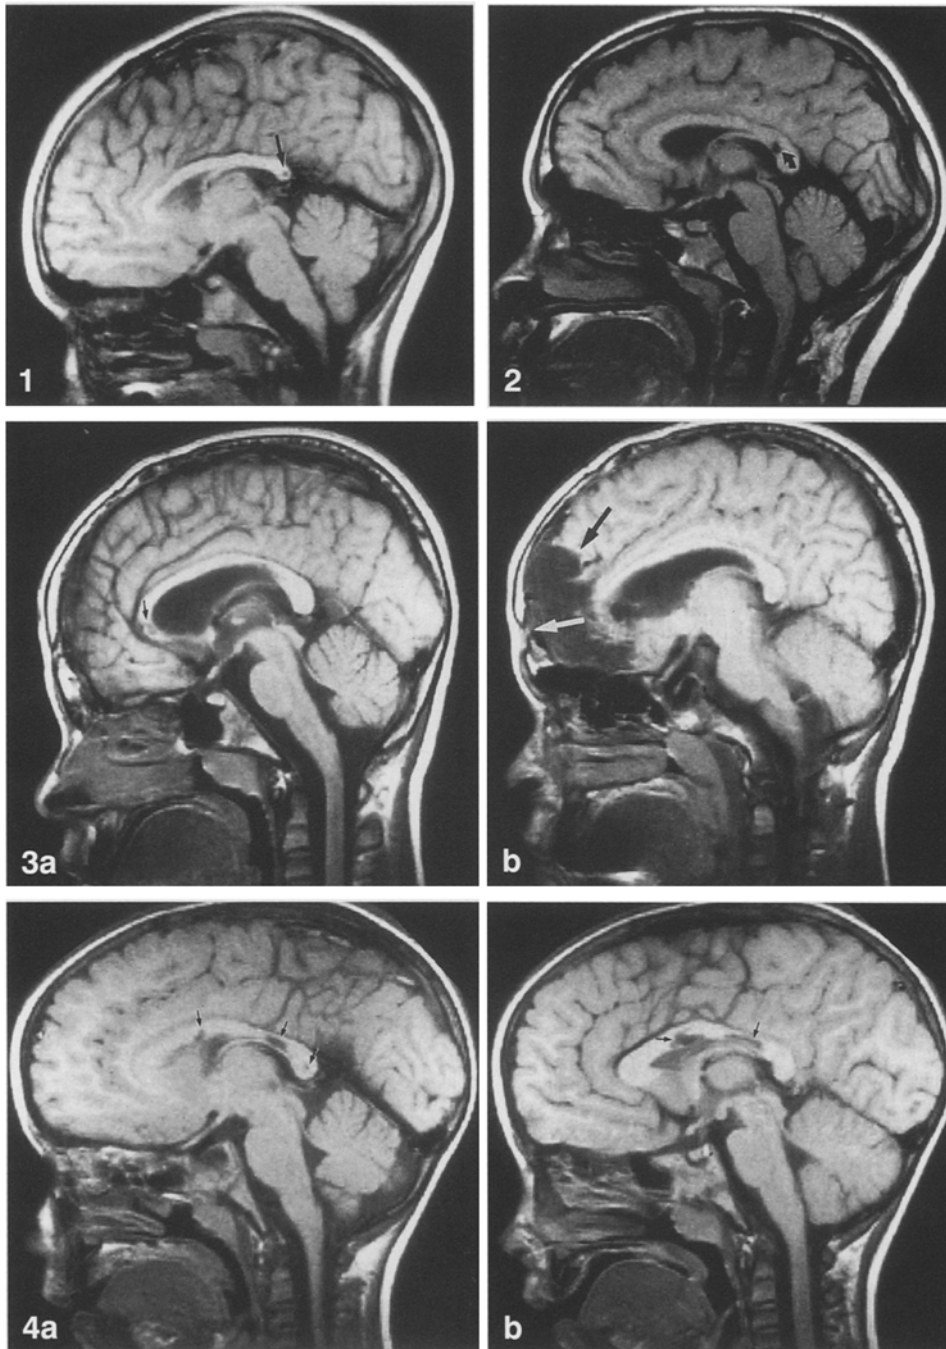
Case 6. Sagittal T1-weighted (600/30) MRI shows a small area of decreased signal (*arrow*) within the splenium of the corpus callosum
